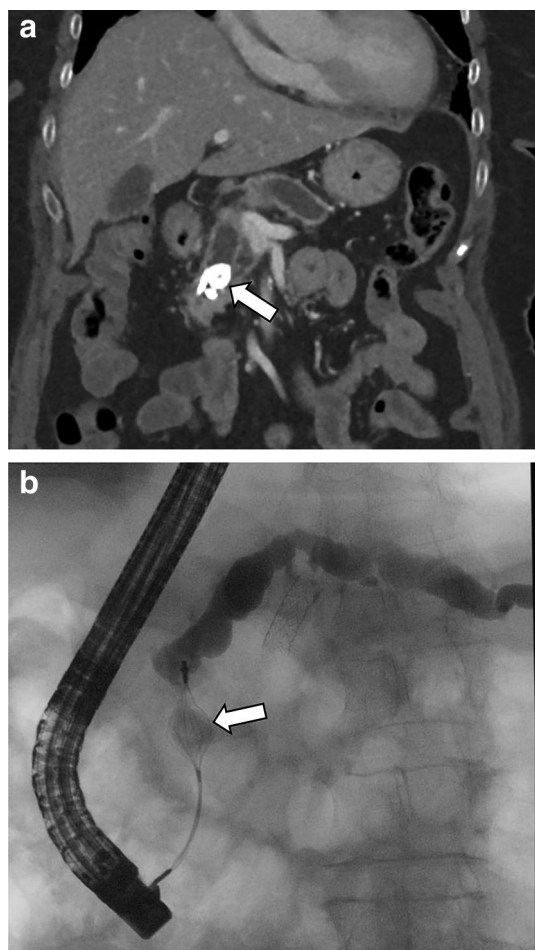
Coronal contrast-enhanced CT demonstrates multiple calculi within the pancreatic duct in the head of the pancreas (arrow in a) with diffusely dilated main pancreatic duct and diffuse pancreatic atrophy, findings compatible with chronic pancreatitis (a). Endoscopic retrieval of stone was performed (arrows in b)
